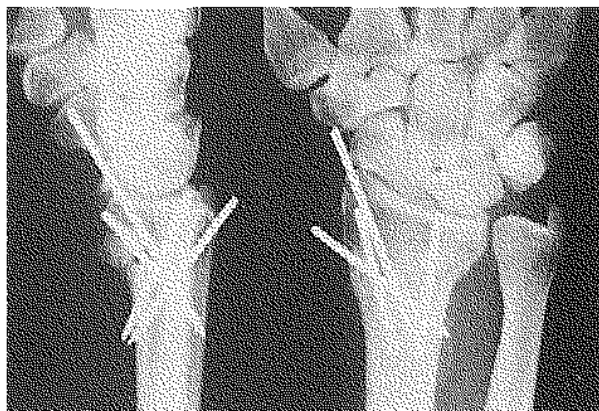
Triquetrolunate instability associated with extra-articular fracture of the distal radius (postoperative xrays).
